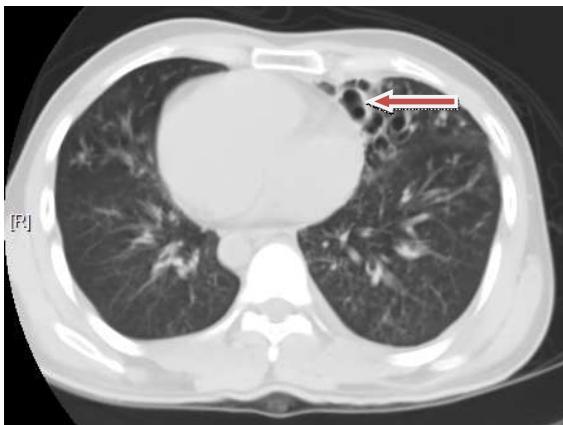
High resolution CT Thorax-Bronchiectatic changes
